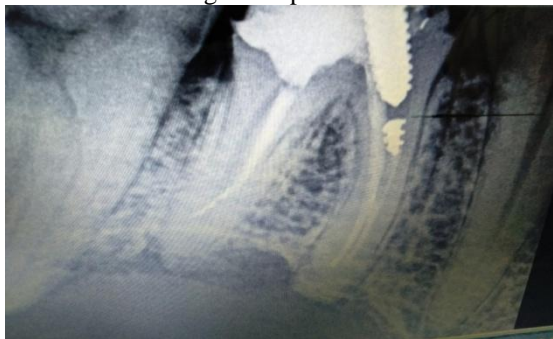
CBCT showing the size of the lesion
